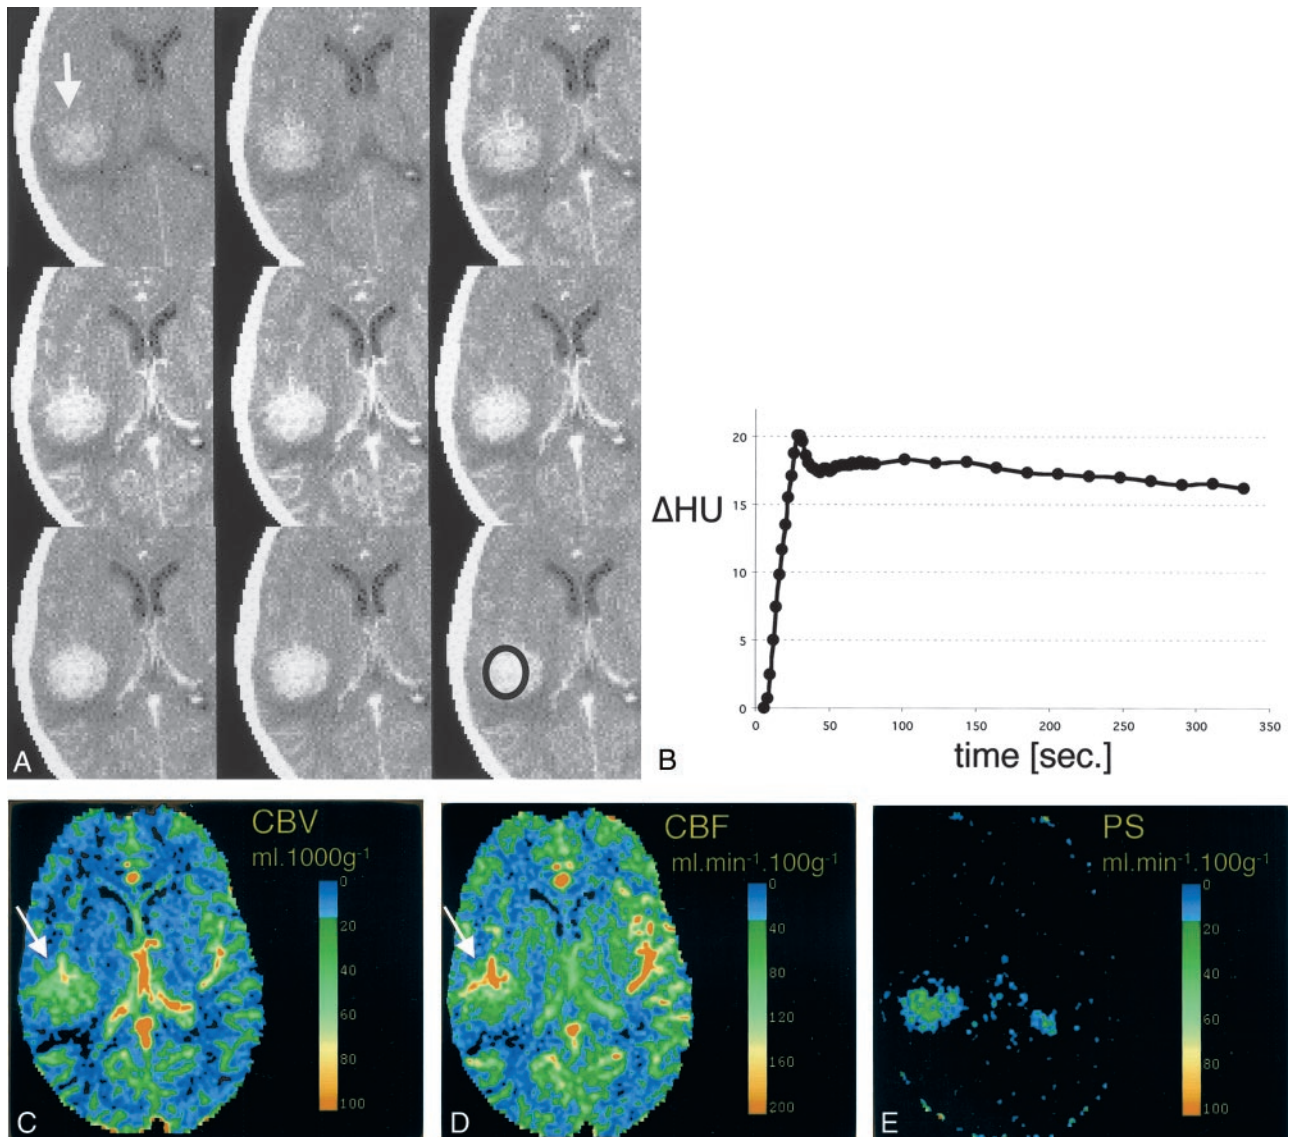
CT scans and data analysis obtained from patient 2.
